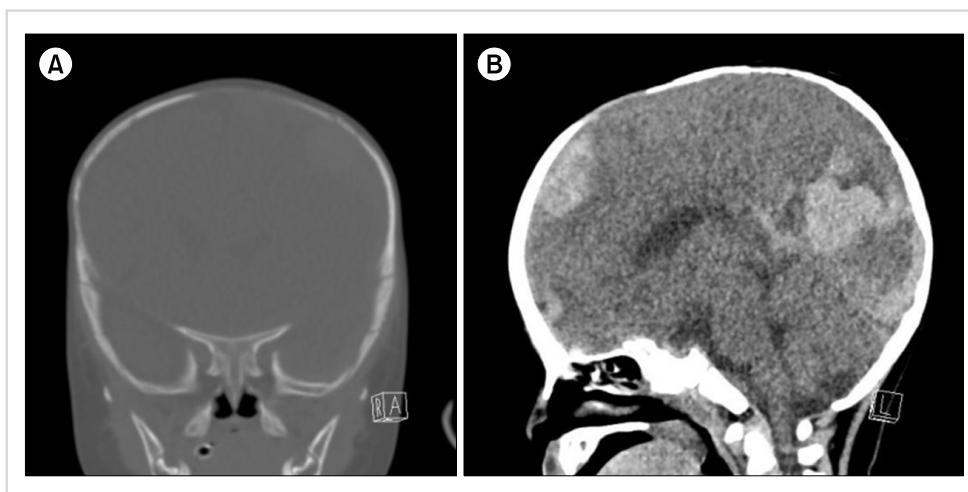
Computed tomography of brain in an infant with severe hemophilia A with intracranial hemorrhage mistaken to be caused by child abuse. (A) Left temporal and parietal bone fractures. (B) Acute epidural hematoma along the entire left hemisphere and falx cerebri, multifocal hemorrhagic contusion of left cerebral hemisphere, associated subfalcine herniation, and brain edema.
